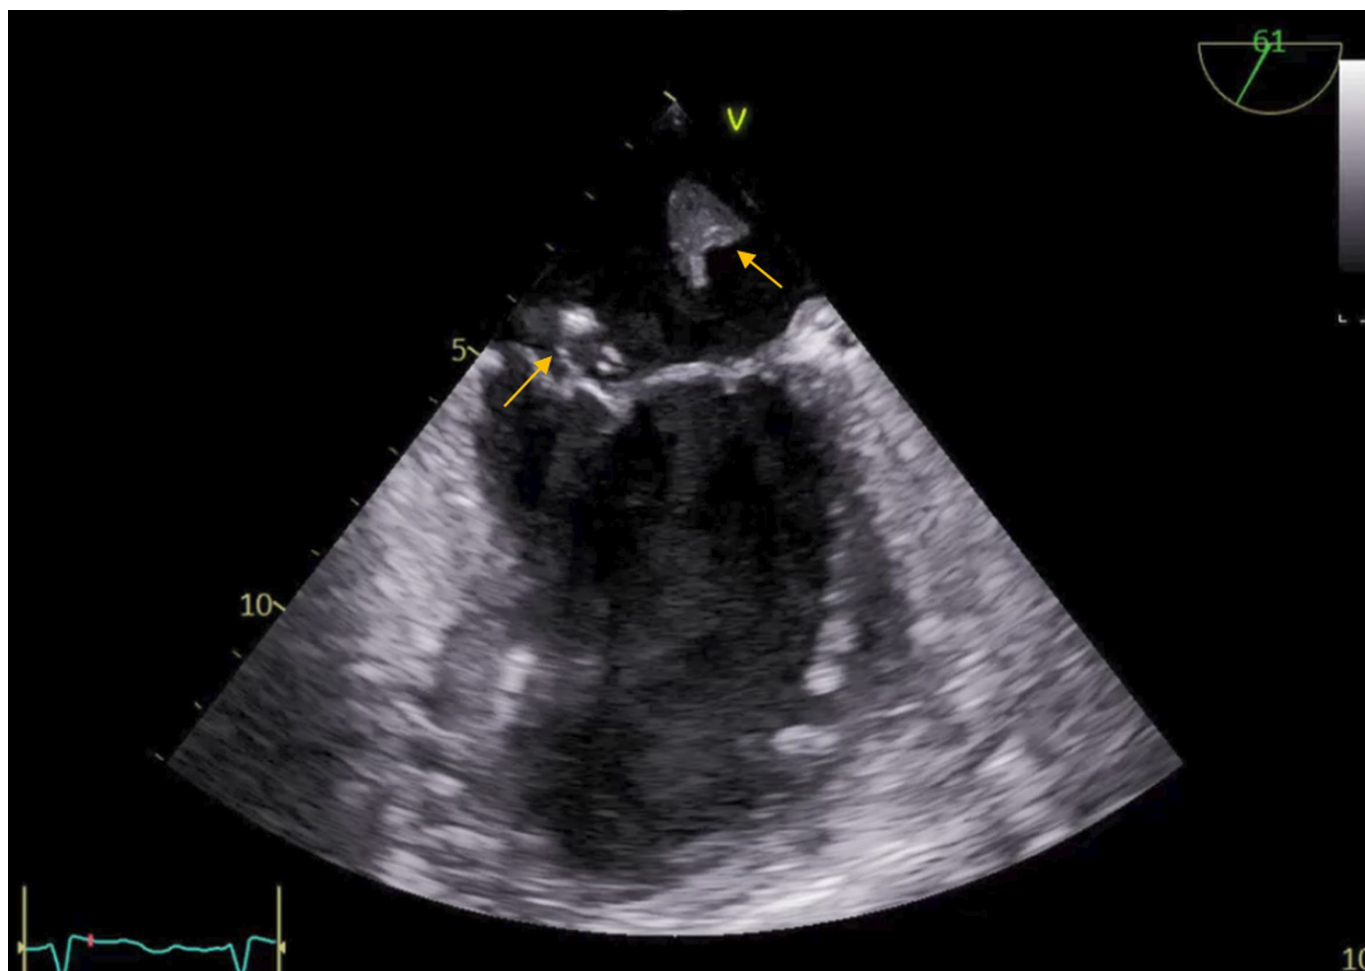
Transoesophageal echocardiography with two inhomogeneous echogenicity vegetations of different age on the mitral valve (arrows).
